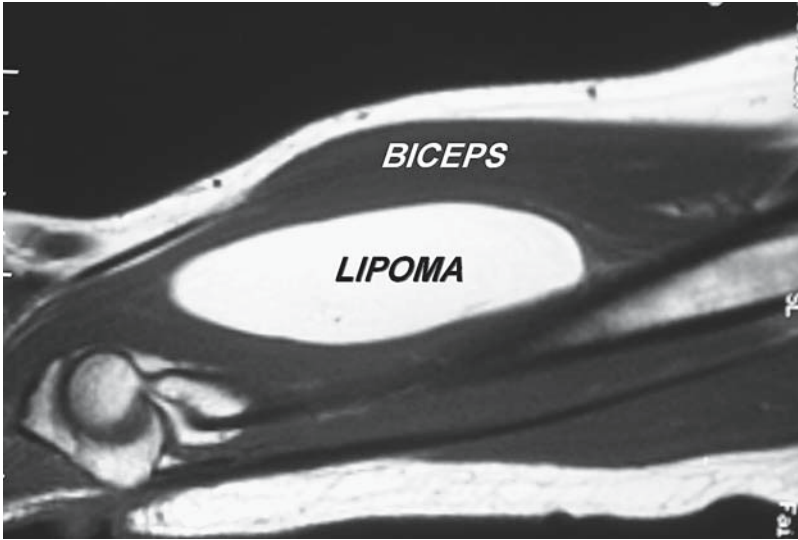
Lipoma. MRI demonstrates an intramuscular lipoma. Note that the tumor has approximately the same level of enhancement as the normal subcutaneous fat, with no heterogeneity noted, as is characteristic of all lipomas.
